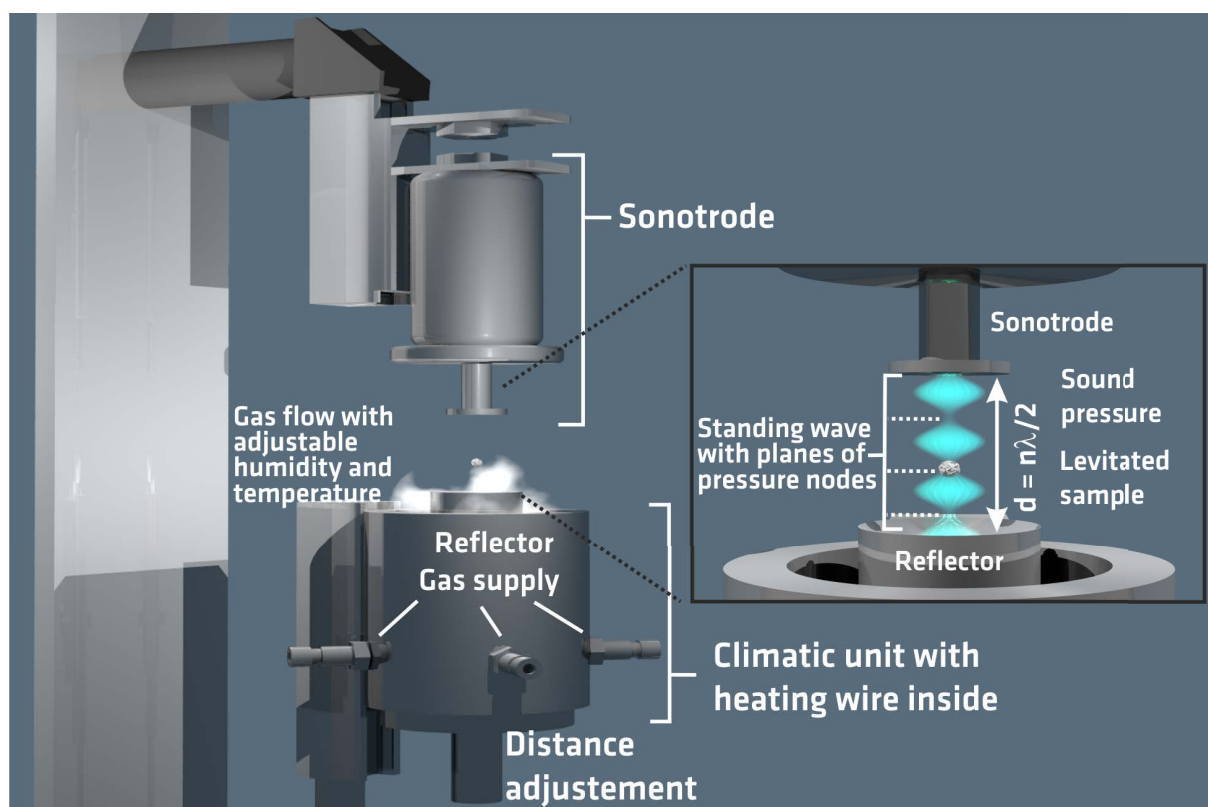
The acoustic levitator serves as a contactless sample holder. The device has three main components: the sonotrode, concentric reflector, and the control unit. The sonotrode emits the ultrasonic field which is delimited by the reflector resulting in a standing wave with pressure nodes.
